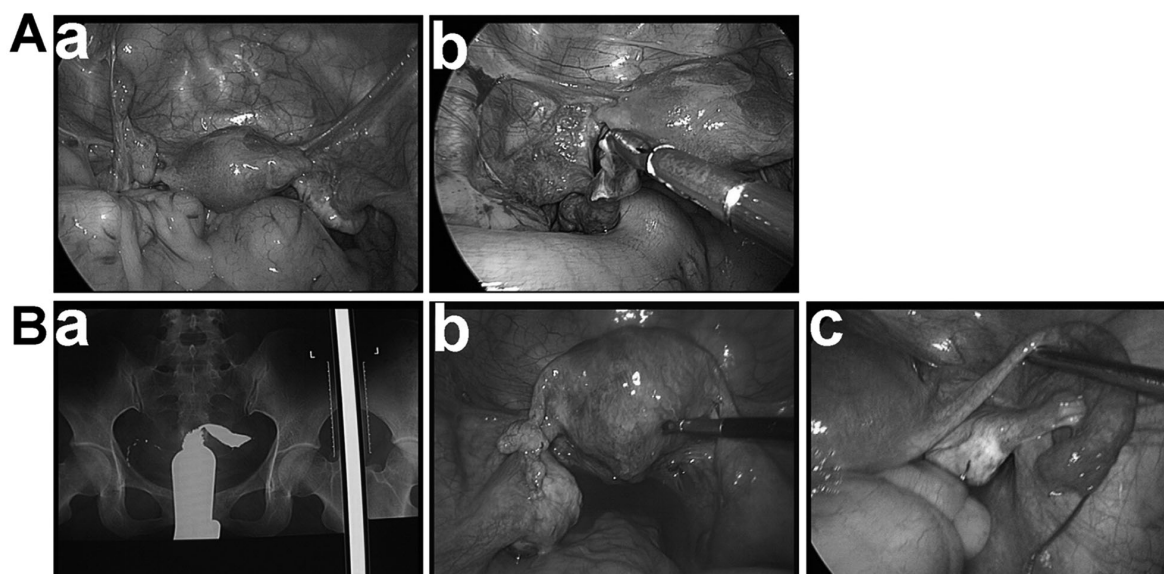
A: Salpingectomy of the right fallopian tube was performed for the treatment of tubal pregnancy and secondary infertility was observed. (a) Laparoscopic exploration was performed and shows that the tubal fimbria adheres to the left lower abdominal wall and could not effectively capture ovum. (b) Adhesiolysis was performed using a laparoscope, and the left fallopian tube was restored to a normal position. Hysteroscopic tubal liquid instillations shows that the tube is unobstructed. The woman became pregnant two months after the operation and had a live birth. B: Laparotomy salpingectomy was performed for resection of the left ampulla and tubal fimbria for the treatment of tubal patency. (a) Uterine iodine oil radiography and (b) laparoscopy-assisted hysteroscopic tubal liquid instillation indicate an obstruction between the right tubal isthmus and ampulla. (c) Tubal patency is restored by laparoscopy-assisted hysteroscopic tubal catheterization in which the guidewire is inserted through the tubal fimbria into the abdominal cavity. This woman became pregnant eight months after the operation and achieved a live birth.
